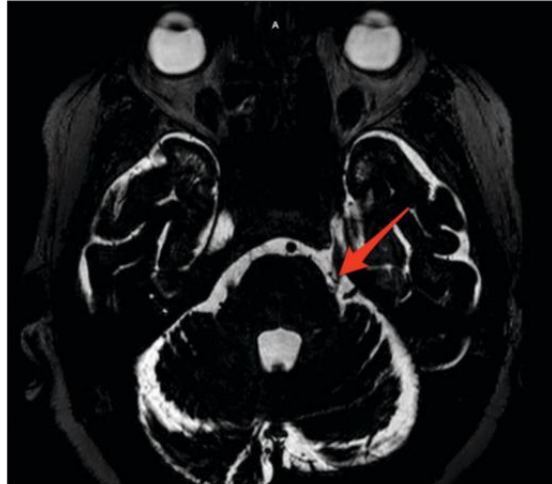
Thin-cut T2 MRI FIESTA sequence image demonstrating the typical appearance of neurovascular contact between a branch of the superior cerebellar artery and the trigeminal nerve entry zone on the left (arrow).
